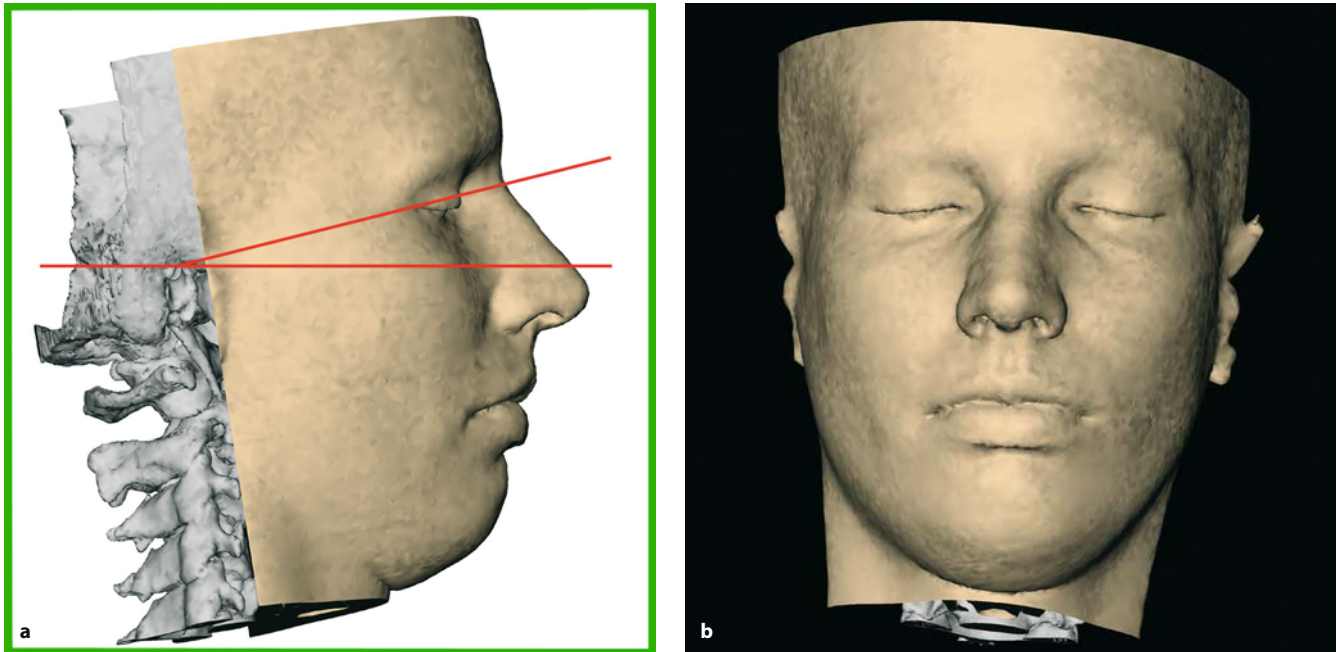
a,b. Modified Caldwell view (patient K.C.). In order to compute the virtual modified Caldwell X-ray, the skull is virtually positioned in the frontal view and posteriorly inclined until the cantho-meatal or trago-canthal line is approximately 23° (15° for children) to the horizontal plane
